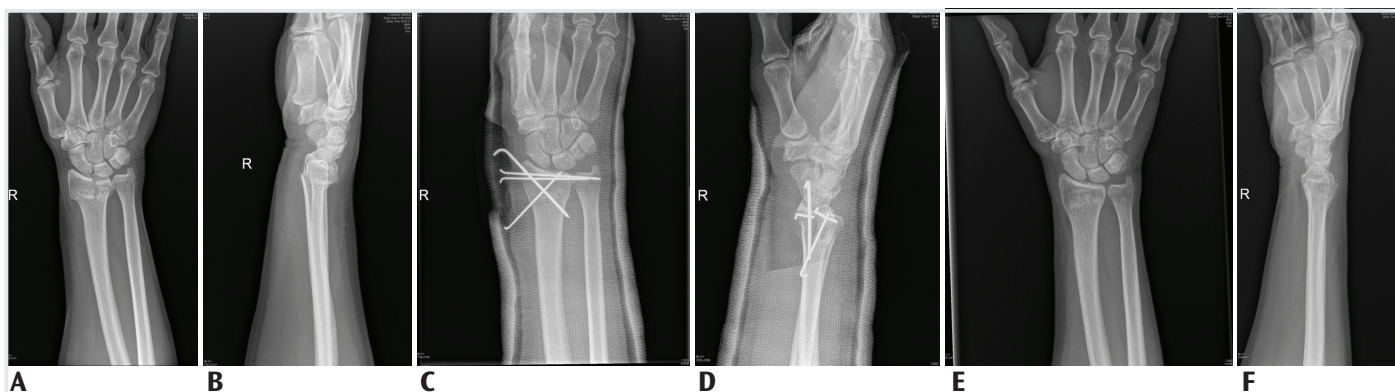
Displaced distal radius fracture operated with the transulnar radial pinning technique. (A) Preoperative anteroposterior X-ray. (B) Preoperative lateral X-ray. (C) Early postoperative anteroposterior X-ray. (D) early postoperative lateral X-ray. (E) Postoperative 12th week anteroposterior X-ray. (F) postoperative 12th week lateral X-ray
